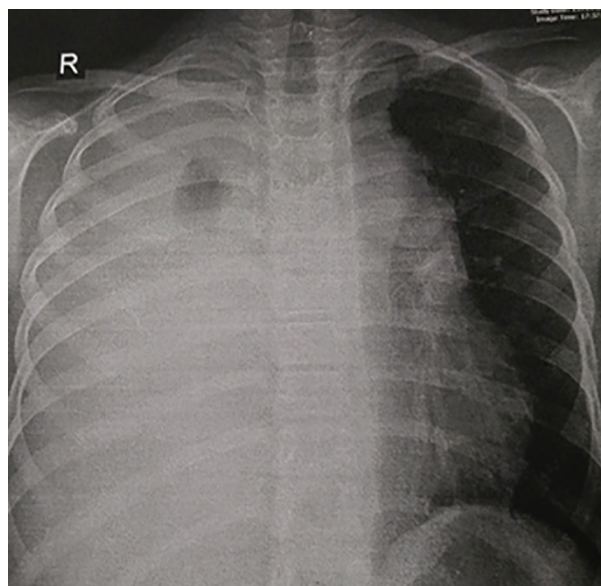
Chest X-ray showing right-sided unilateral white lung.
